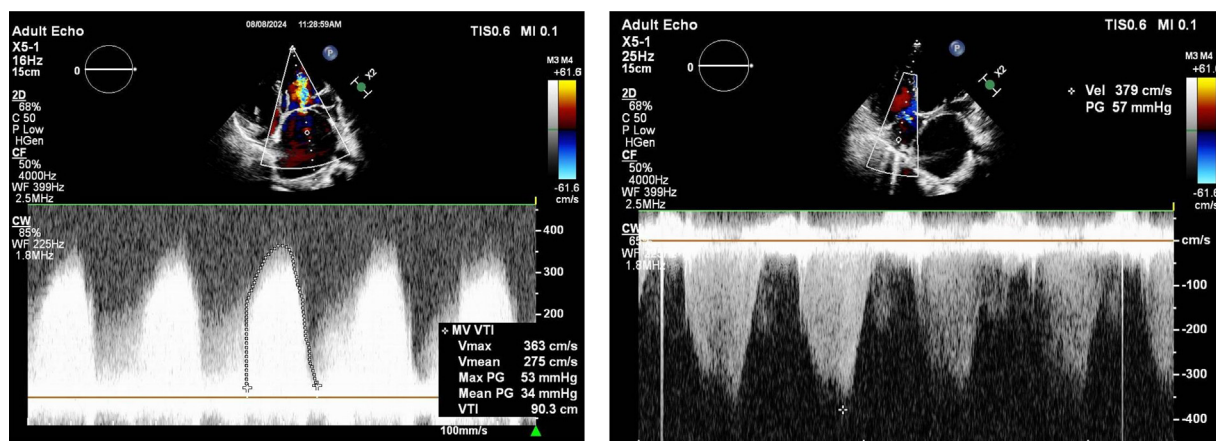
Transthoracic Echocardiography Apical 4 chambers view showing high pressure gradient across the membrane (34mmHg) and high pulmonary artery systolic pressure of 57 mmHg and mild tricuspid regurgitation.
